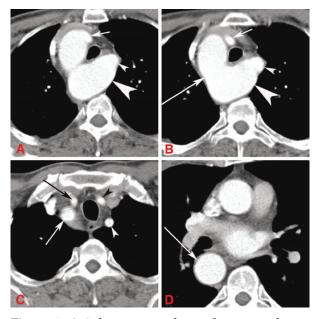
Axial contrast enhanced computed tomography scan of the thorax. The left common carotid artery (small arrows in A and B) is the first branch to arise from the right-sided aortic arch (long arrow in B). The left subclavian artery (small arrowheads in A, B and C) is the last branch to arise from Kommerell's diverticulum, a focal dilatation of the arch (large arrowhead in A and B). The black arrowhead points to the left common carotid artery, the black arrow to the right common carotid artery and the medium sized white arrow to right subclavian artery (C). The descending aorta continues inferiorly on the right side of the vertebral column.
